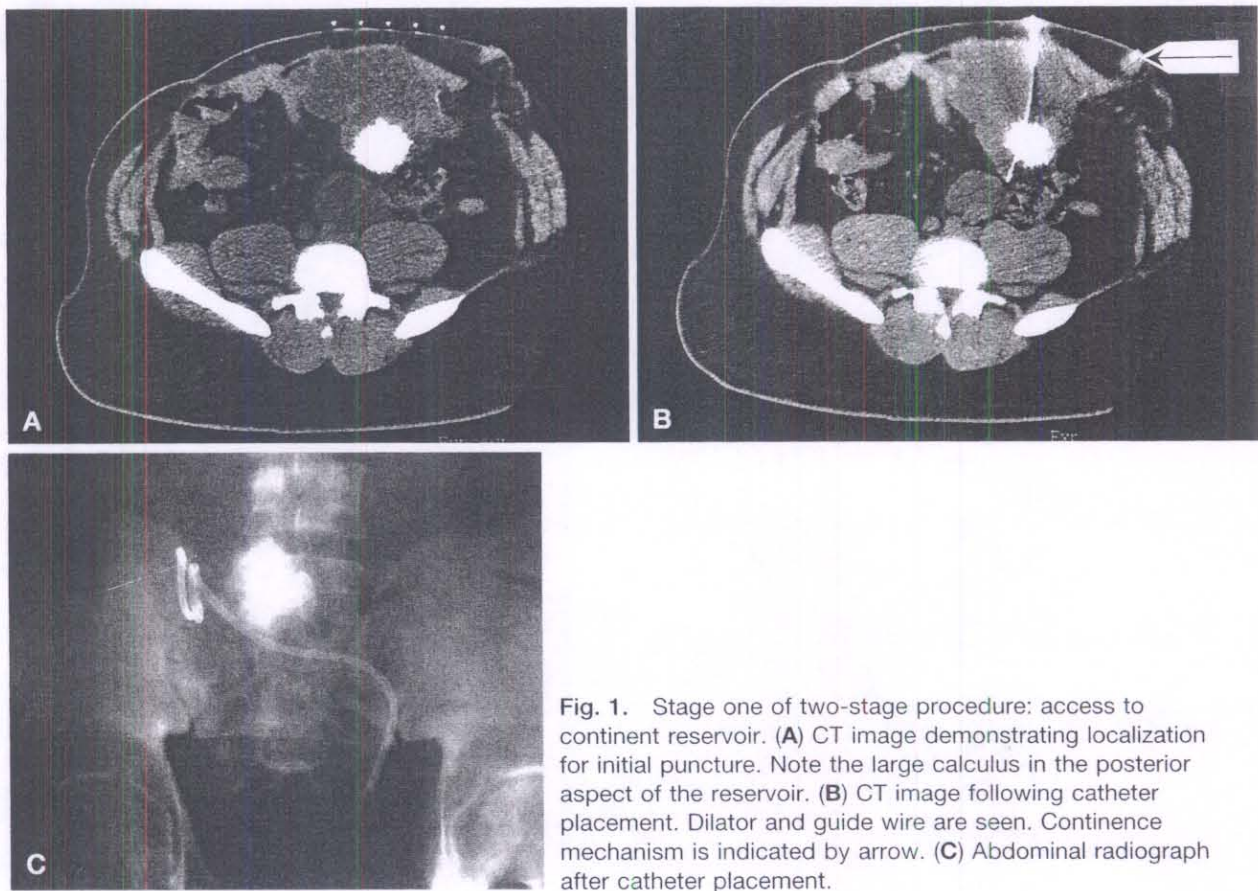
Stage one of two-stage procedure: access to continent reservoir. (A) CT image demonstrating localization for initial puncture. Note the large calculus in the posterior aspect of the reservoir. (B) CT image following catheter placement. Dilator and guide wire are seen. Continence mechanism is indicated by arrow. (C) Abdominal radiograph after catheter placement.
